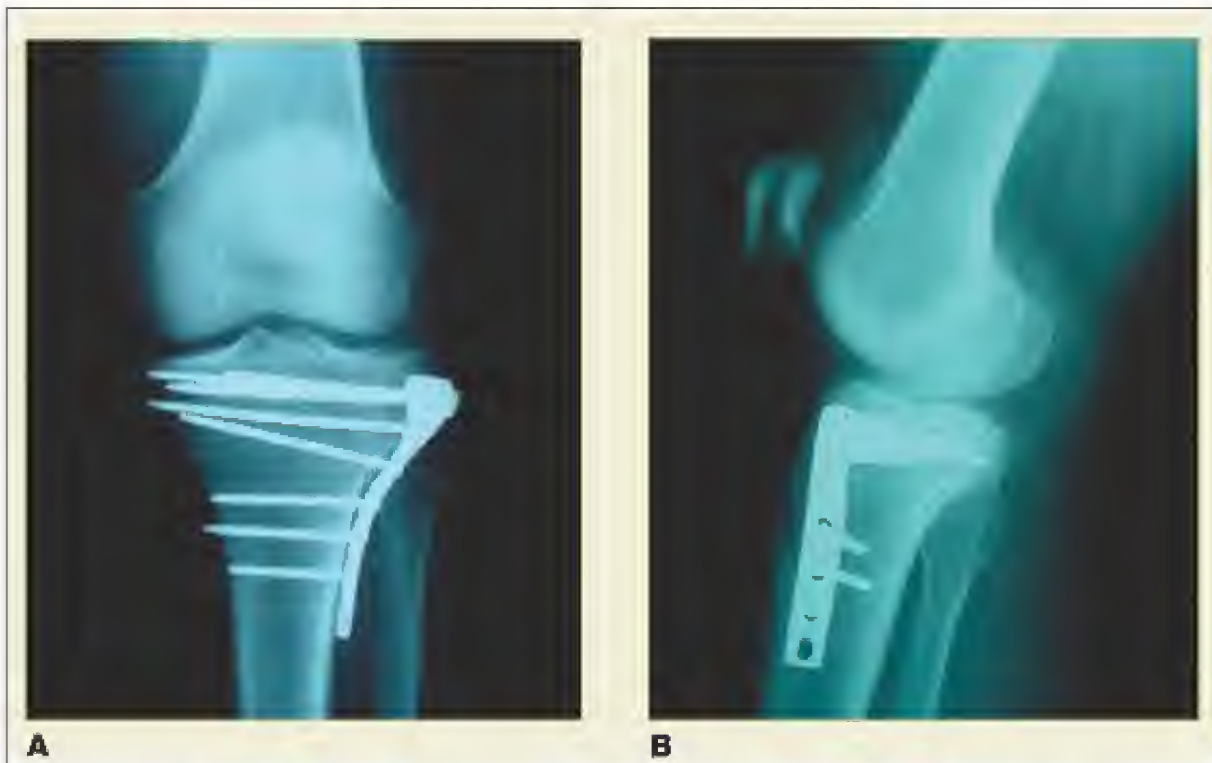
Postoperative AP (A) and lateral (B) radiographs of the knee of the same patient after operative reduction with internal fixation. After 8 weeks of non-weight bearing and 4 more weeks of gradual toe touch and rehabilitation, the patient had no further complications.
